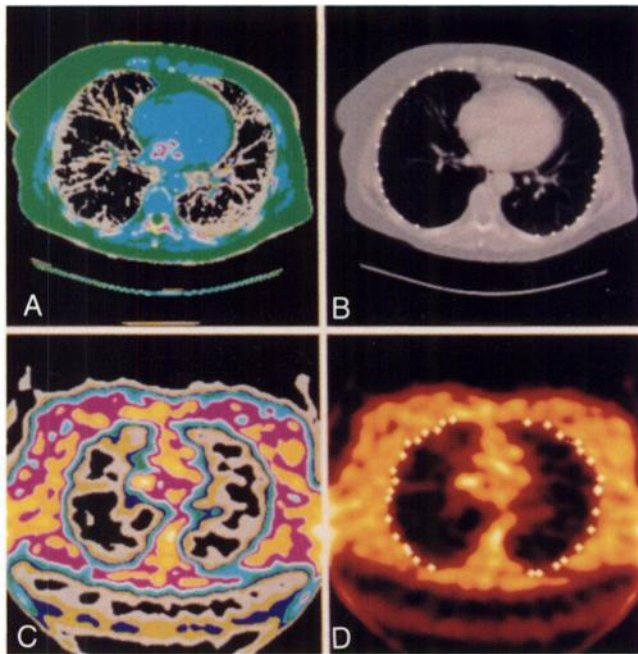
Contours used for registration. (A,C) CT and PET transmission scans, respectively, displayed in an isocontour color table. The isocontour images helped us to determine the contours to be used in the registration procedure. The points defining the contours are shown as points overlaid on the images (B,D).
